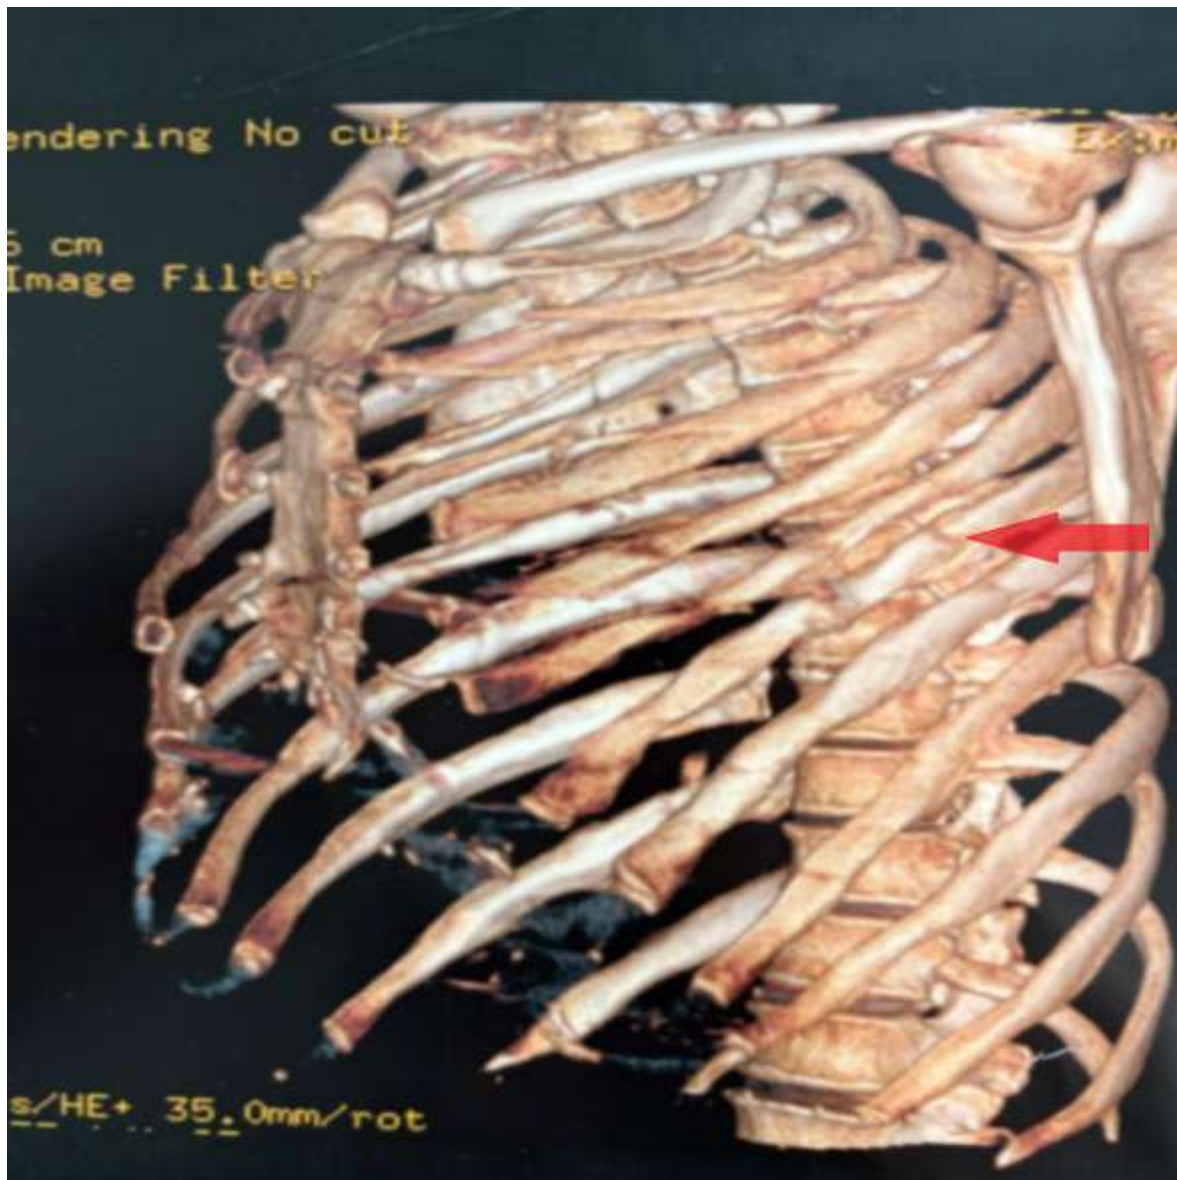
Three-dimensional reconstruction by computed tomography (CT) showing a fracture of the 5th left rib (arrow).
